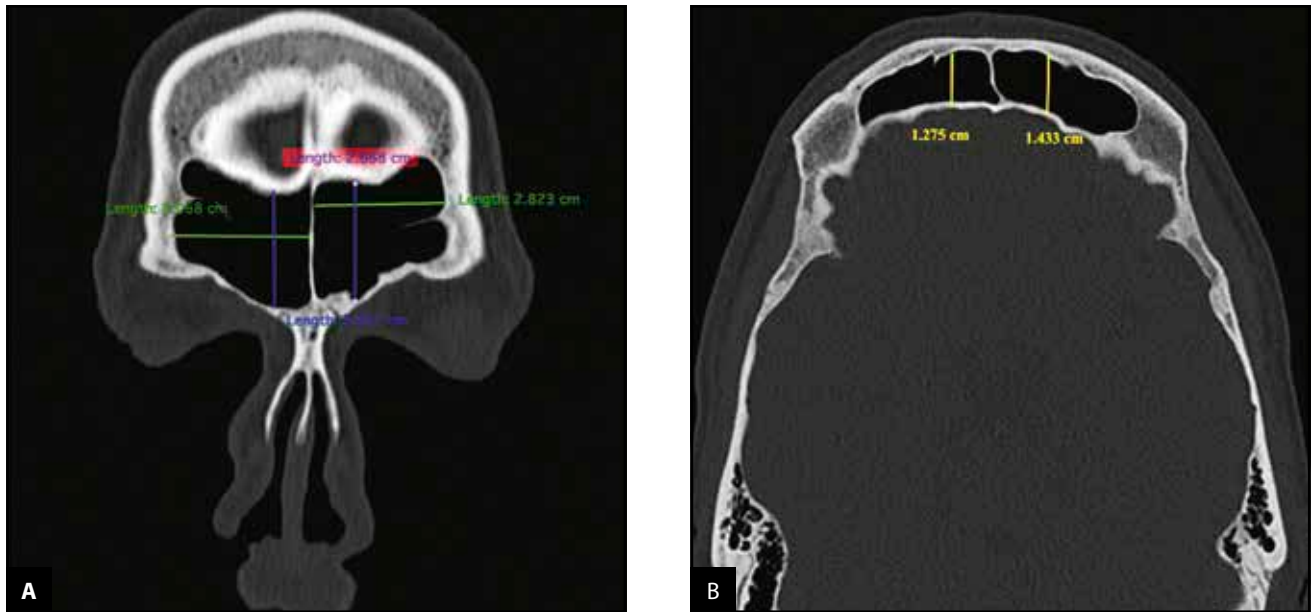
Example of native cranio-facial CT image slice, showing measurement of the frontal sinus: A. (coronal view) normal height (blue lines) and width (green lines); B. (axial view) anteroposterior length (yellow lines).
